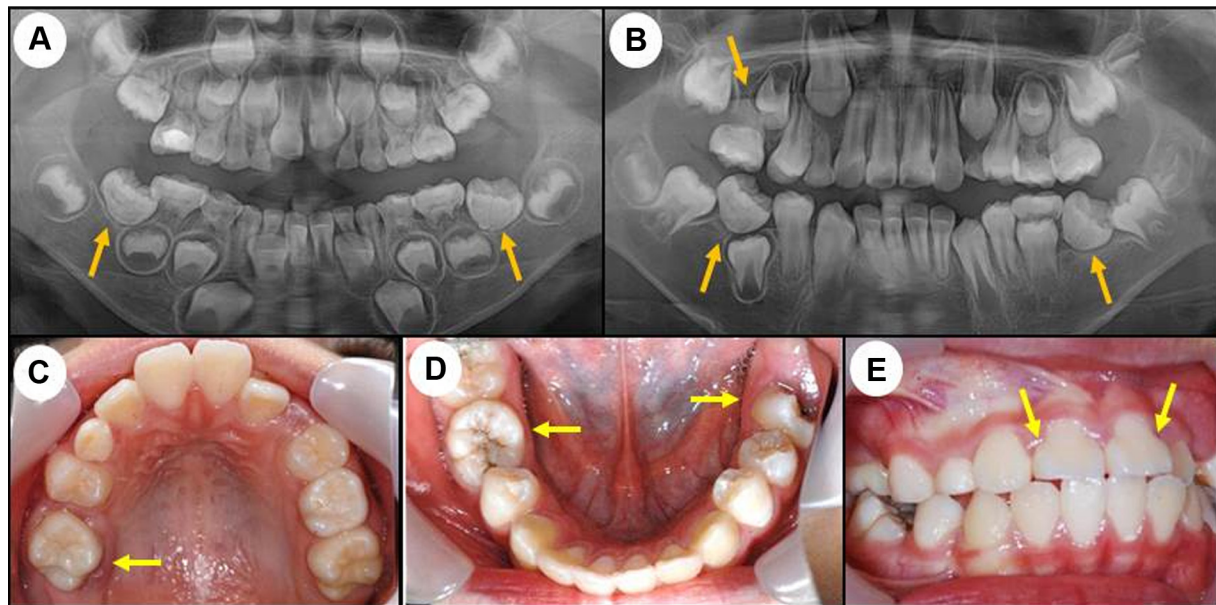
Case 2 (patient 2). Clinical photographs and radiographic films. A, Panoramic film obtained at the first visit. The roots of the upper bilateral first permanent molars and upper and lower bilateral second primary molars appear to be thin and divergent, and constriction of the pulp cavities is evident. The roots of the lower bilateral first permanent molars are not formed (yellow arrows), and the distal root of the lower right second primary molar is resorbed owing to mesial tilting of the lower right first permanent molar. B, Panoramic film obtained at 3 years, 7 month after the first visit. The lower right second primary molar underwent early exfoliation owing to mesial tilting of the lower right first permanent molar, which also obstructed the eruption path of the lower right second premolar (lower left yellow arrow). The eruption space for the upper right second premolar is insufficient owing to early exfoliation of the upper right second primary molar (upper yellow arrow), and distal tilting of the lower left first permanent molar is obstructing the eruption path of the lower left second permanent molar (lower right arrow). C, At 4 years and 1 month after the first visit, the clinical intraoral photograph (maxilla) of this boy (at 9 years and 11 months old) reveals space loss due to early exfoliation of the upper right second primary molar and mesial rotation of the upper right first permanent molar (yellow arrow). D, Clinical intraoral photograph (mandible) obtained at the same time as C. The lower right first permanent molar exhibits moderate dental caries, and its mesial tilting is obstructing the eruption path of the lower right second premolar (yellow arrows). In addition, the lower left first permanent molar exhibits moderate dental caries, and its distal tilting is obstructing the eruption path of the lower left second permanent molar. E, Clinical intraoral photograph (right) obtained at the same time as C. A wedge-shaped defect is evident on the labiocervical surface of the upper incisors (yellow arrows).
